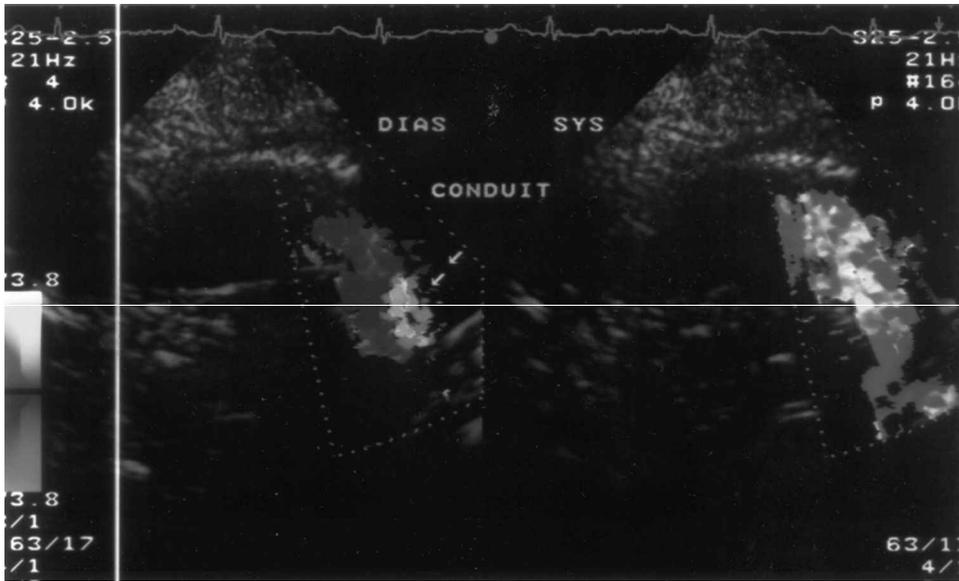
TTE with color-flow Doppler at the apex demonstrates conduit prosthetic valve regurgitation in diastole (left side) and continued laminar flow in systole (right side).
